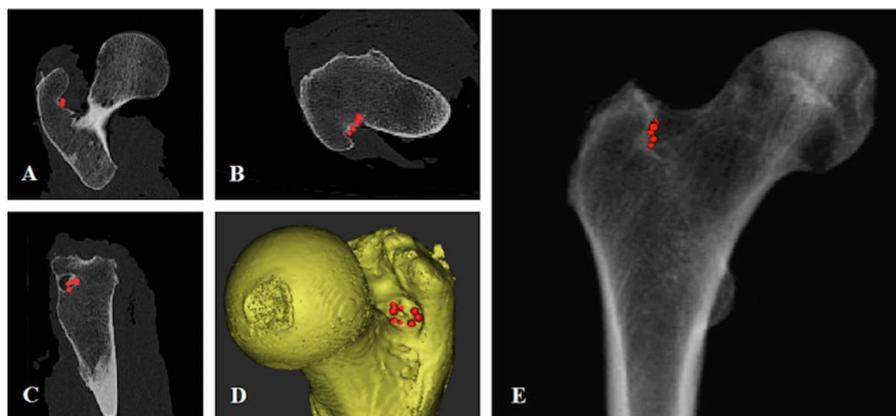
A-E (A) A coronal CT slice showing the most distal wand point on the intersection of the vertical wall of the trochanteric fossa and the oblique intertrochanteric crest. (B) Axial and (C) sagittal CT slices showing the circular tendon inserting into the groove-shaped trochanteric fossa. (D) A 3-D CT model of a proximal femur showing the recorded wand points indicating the external obturator footprint in the trochanteric fossa. (E) Averaged intensity projection (AIP) image showing what a conventional radiograph of this femur would look like. Red marks in each image are the locations of the wand points.
